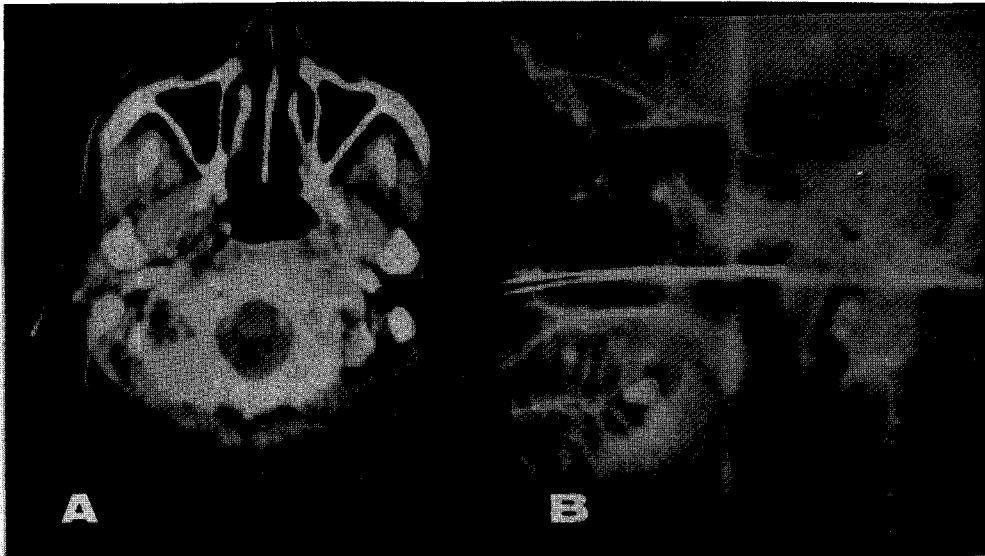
CT scan (A) shows residual tumor of the left posterior nasopharynx after 7000 rad external radiotherapy. Lateral view of applicator in nasopharynx (B).
